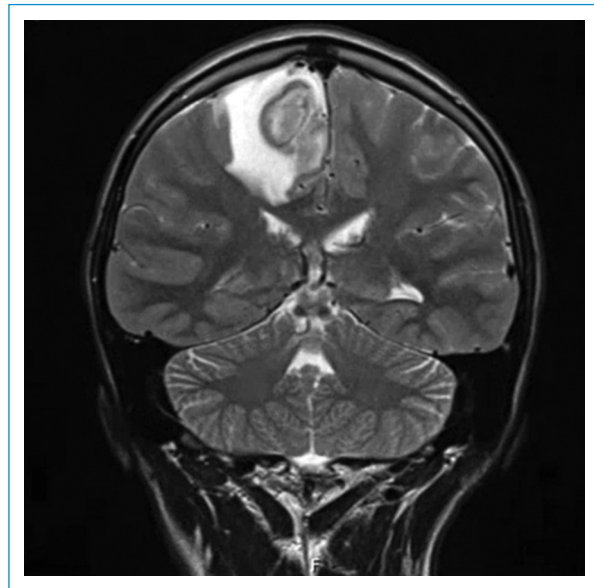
MRI, coronal plane.
